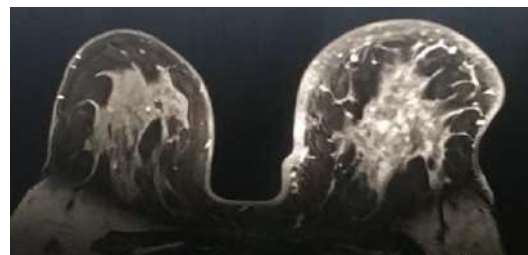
Axial section of T1W post contrast FAT SAT MRI breast showing multiple small enhancing lesions in central breast parenchyma of left breast with trabecular and overlying skin thickening
